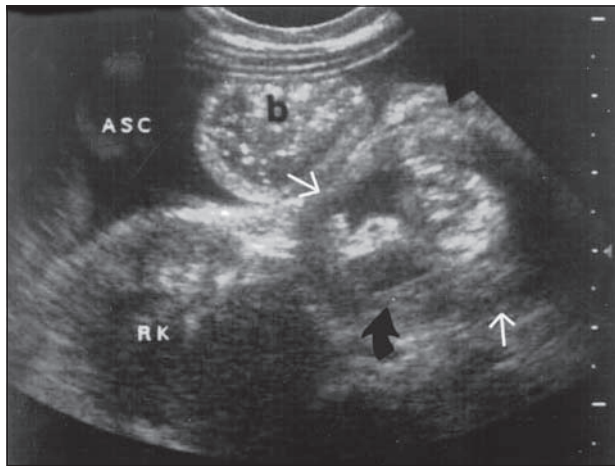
Intussusception: Ultrasound of the right abdomen shows a donut-shaped mass (arrows). Asc = ascites; RK = right kidney; b = dilated bowel loop.
